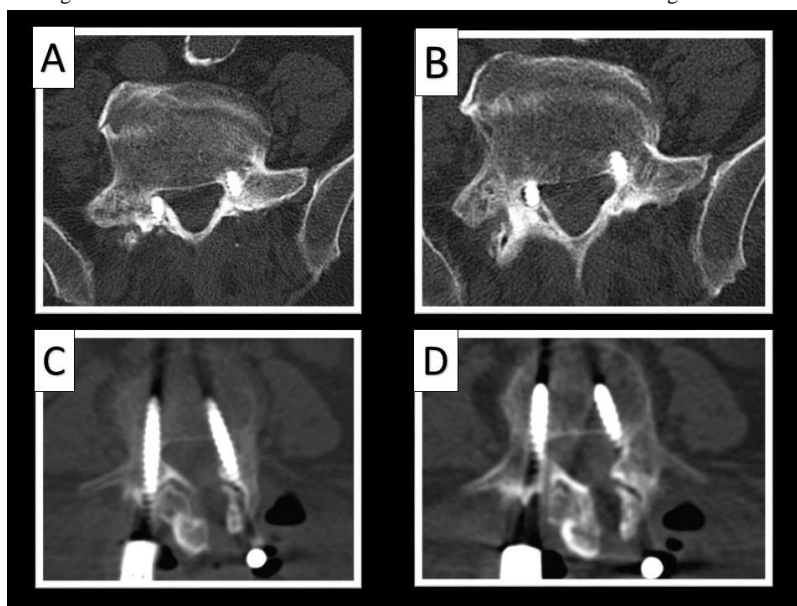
Postoperative CT in patients with medialized screws and invasion of the canal.
